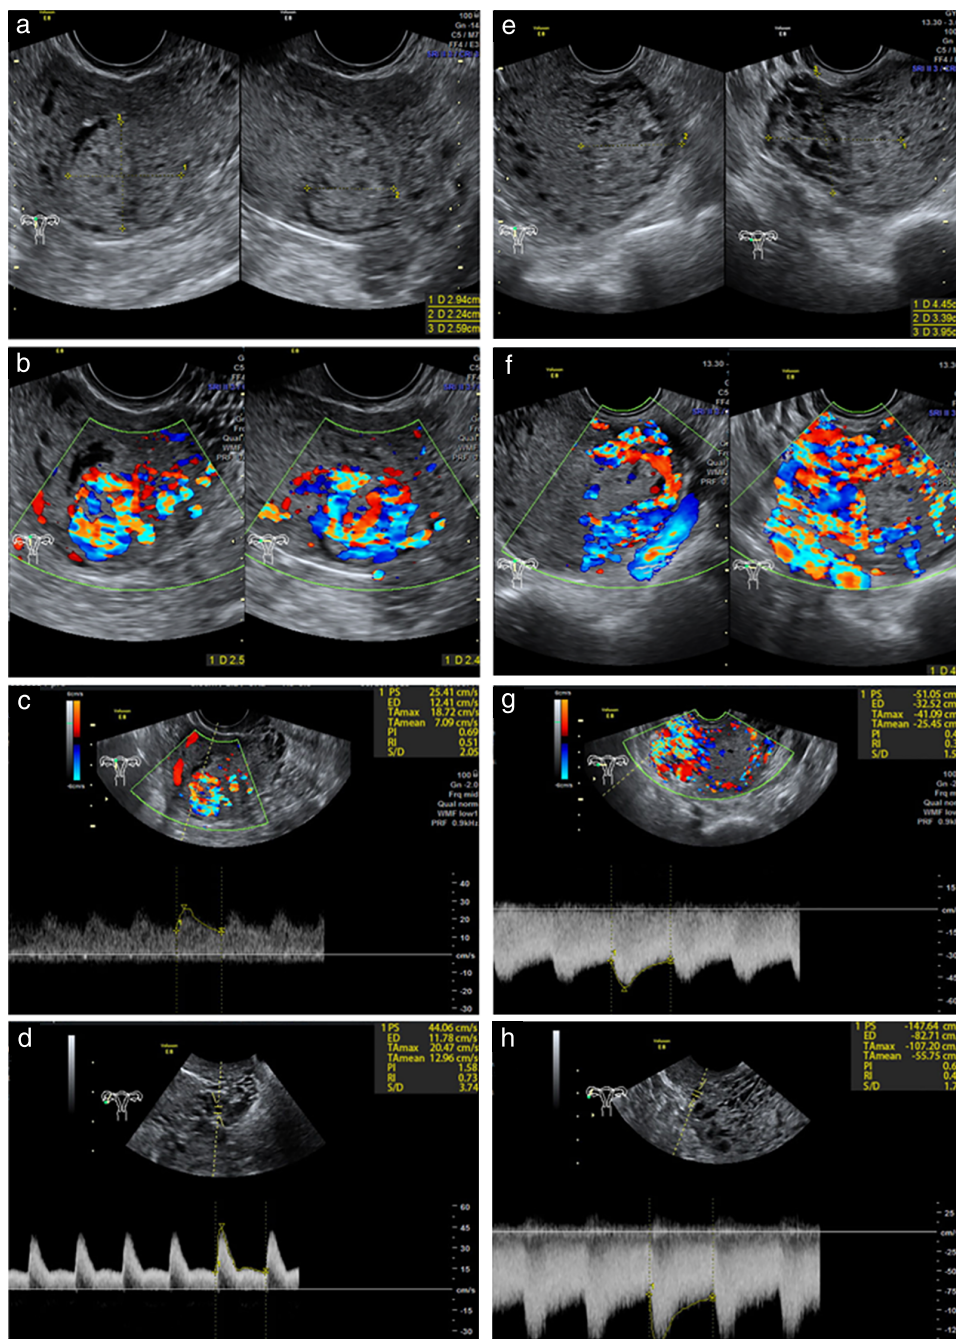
Grayscale (a,e) and Doppler (b–d, f–h) images and measurement of hemodynamic parameters of tumor central vessels (c,g) and of uterine artery (d,h) in a patient with low-risk gestational trophoblastic neoplasia (GTN) who responded to methotrexate (MTX) treatment (a–d) and in a patient with low-risk GTN with MTX resistance (e–h). (a–d) This 28-year-old woman (International Federation of Gynecology and Obstetrics (FIGO) Stage I and FIGO score 1) was predicted to be MTX responsive by the Doppler-based model (calculated value of -2.0762). Before MTX therapy, her serum human chorionic gonadotropin (hCG) was 4441 IU/L, the uterine lesion measured $2.9 \times 2.6 \times 2.2$ cm and time-averaged mean velocity in the uterine artery (UtA-TAmean) was 12.96 cm/s. After five cycles of MTX, her serum hCG declined to 2.52 IU/L. (e–h) This 44-year-old woman (FIGO Stage III and FIGO score 4) was predicted to be MTX resistant by the Doppler-based model (value of 0.69420). Before MTX therapy, her serum hCG was 54 288 IU/L, the uterine lesion measured $4.5 \times 4.0 \times 3.4$ cm and UtA-TAmean was 55.75 cm/s. During the first three cycles, her serum hCG fluctuated on a plateau level. She was then changed to actinomycin-D treatment.
